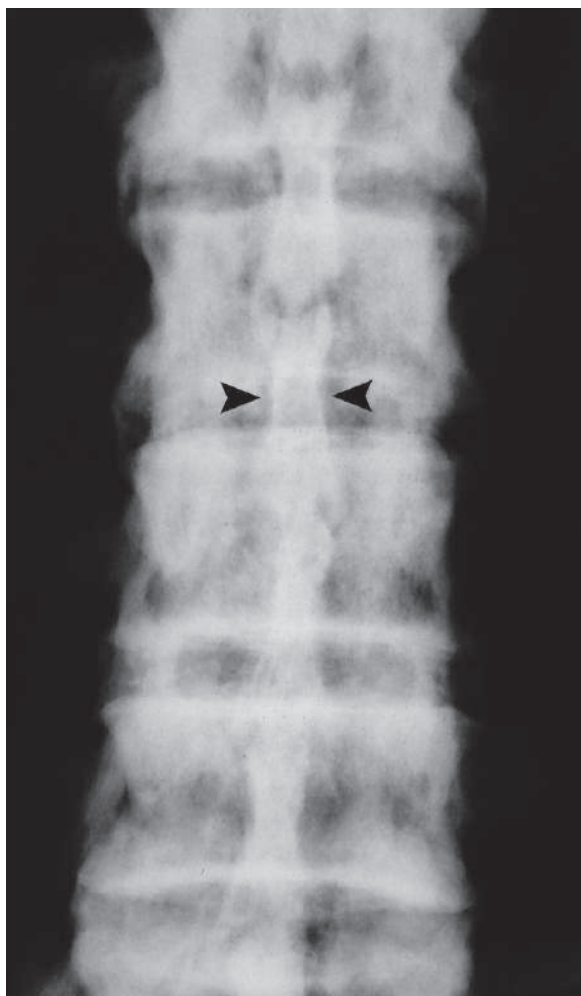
Anteroposterior plain radiograph of the thoracic spines of the same patient shows severe vertebral and paravertebral ligaments sclerosis (poker back). Calcification of the supraspinous ligament results in the classical “dagger sign” that is usually seen in ankylosing spondylitis (*arrowheads*)
